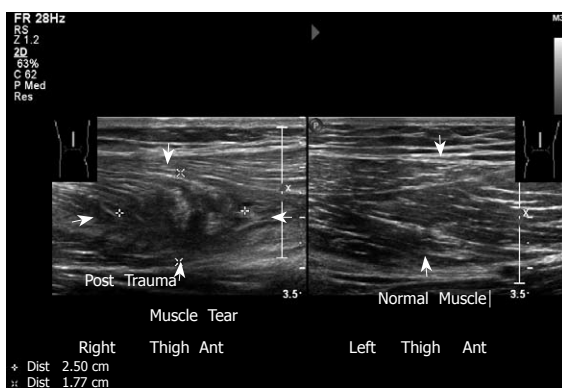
Longitudinal sonogram of the thigh. A young basketball player presented with pain over the anterior aspect of the distal right femur. Note the irregularity with partial tear of the muscle. Left thigh: Normal appearance.
